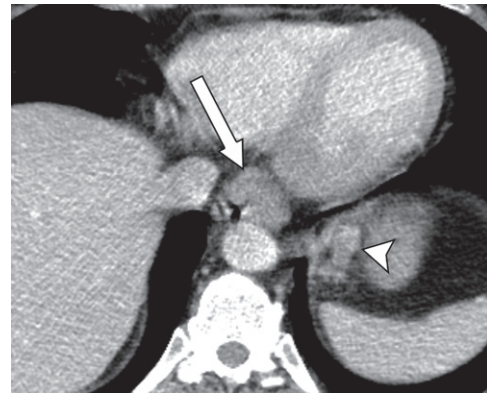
Esophageal carcinoma with adjacent lymphadenopathy in a 48-year-old man who presented with dysphagia, weight loss, and occult GI bleeding. Axial portal venous phase CT image shows moderate asymmetric distal esophageal wall thickening consistent with the biopsy-confirmed poorly differentiated adenocarcinoma (arrow), with adjacent lymphadenopathy (arrowhead). Figure E2 is an endoscopic image in this patient that shows the esophageal mass, with an area of hemorrhage.
